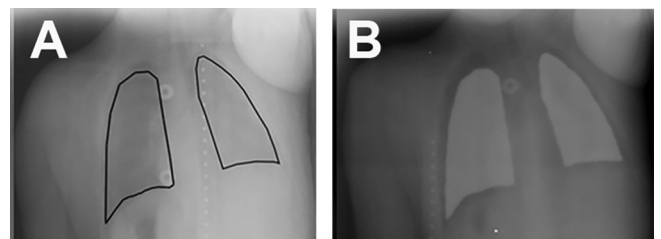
Lung blocks. Block delineation on PA X-ray image in lateral decubitus position (A). Verification of block position with megavoltage X-ray image during treatment (B).
